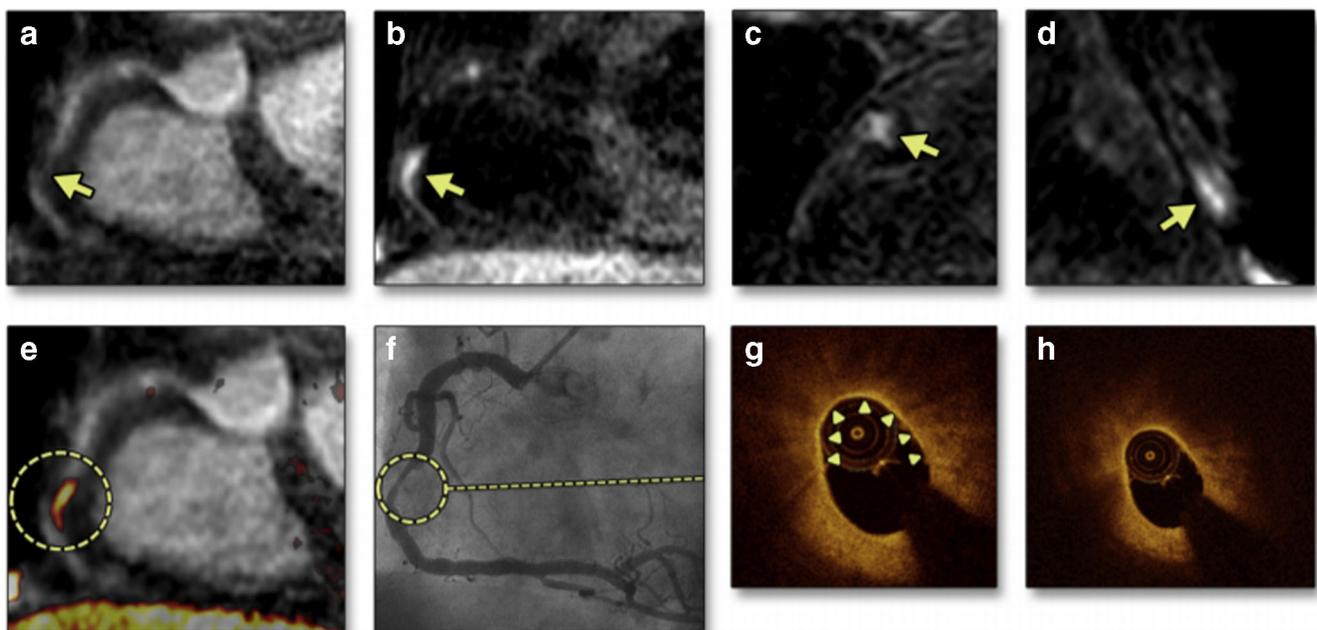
a Coronary magnetic resonance angiography (MRA) revealed significant mid right coronary artery (RCA) stenosis (arrow). b–d T1-weighted imaging showed intrawall high-intensity signal (HIS) (arrows): b oblique, c axial, and d long-axis image. e Fused image showed intrawall HIS (circle). f X-ray coronary angiography revealed
